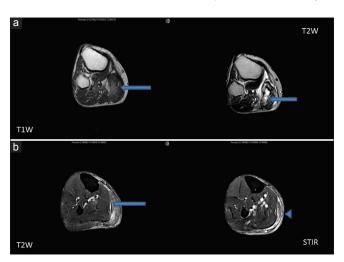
(a) T1 and T2-weighted axial sections of right lower limb show areas of hyperintensity in the proximal part of right gastrocnemius muscle (arrow) suggestive of hemorrhage (arrow head). (b) T2-weighted and STIR axial sections of right lower limb shows diffuse swelling and hyperintensity of medial gastrocnemius muscle suggestive of edema and presence of fluid in intermuscular plane (arrow) and around medial gastrocnemius muscle (arrow head)
